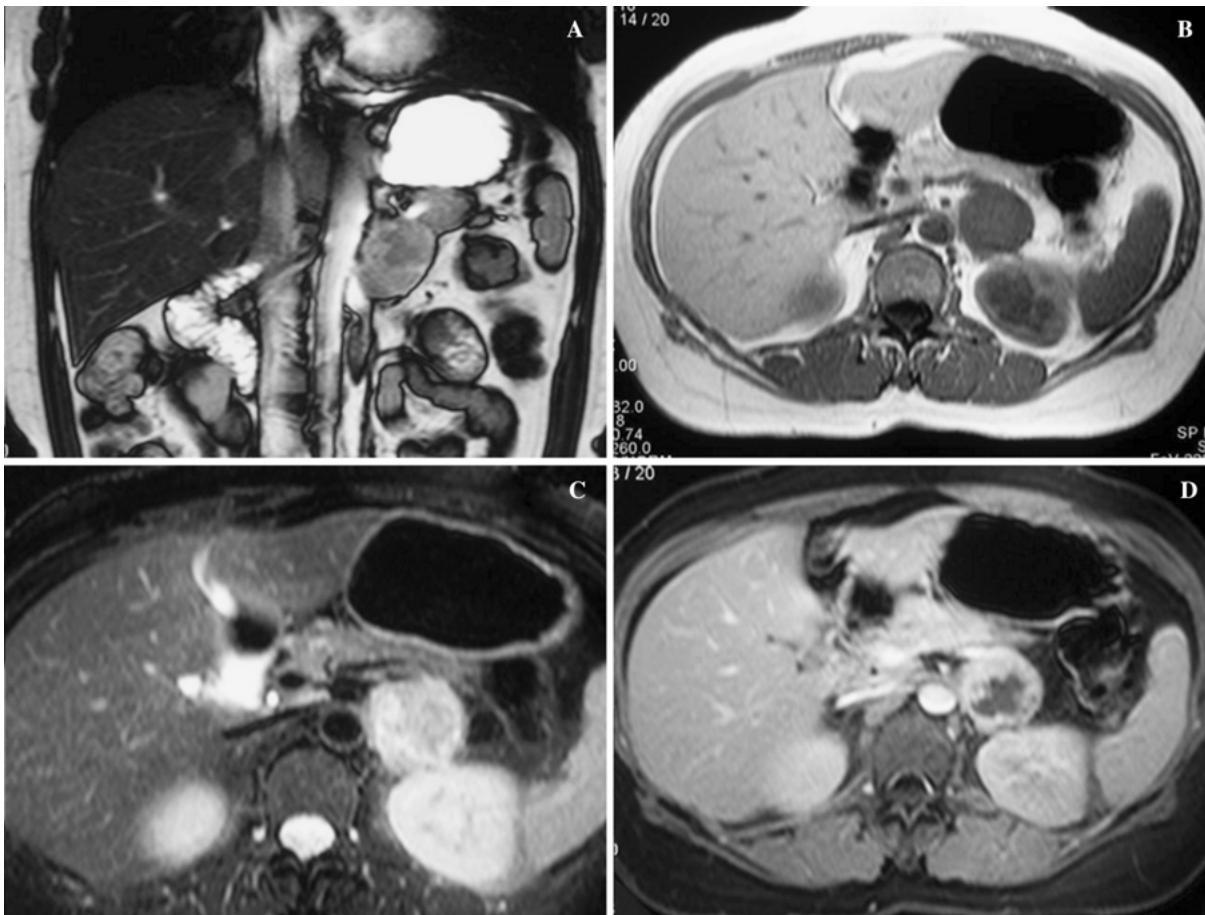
Magnetic resonance images of a 3-cm left adrenal leiomyosarcoma. A T2-weighted, balanced, steady-state, free precession sequence (true fast imaging with steady state free precession [FISP]; repetition time [TR]/echo time [TE]/flip angle [FA] = 4.3 ms/2.1 ms/72 degrees) in coronal section shows a heterogeneous mass in the left suprarenal area. B T1-weighted spoiled gradient echo sequence (two-dimensional fast low-angle shot; TR/TE/FA = 150 ms/1.8 ms/70
